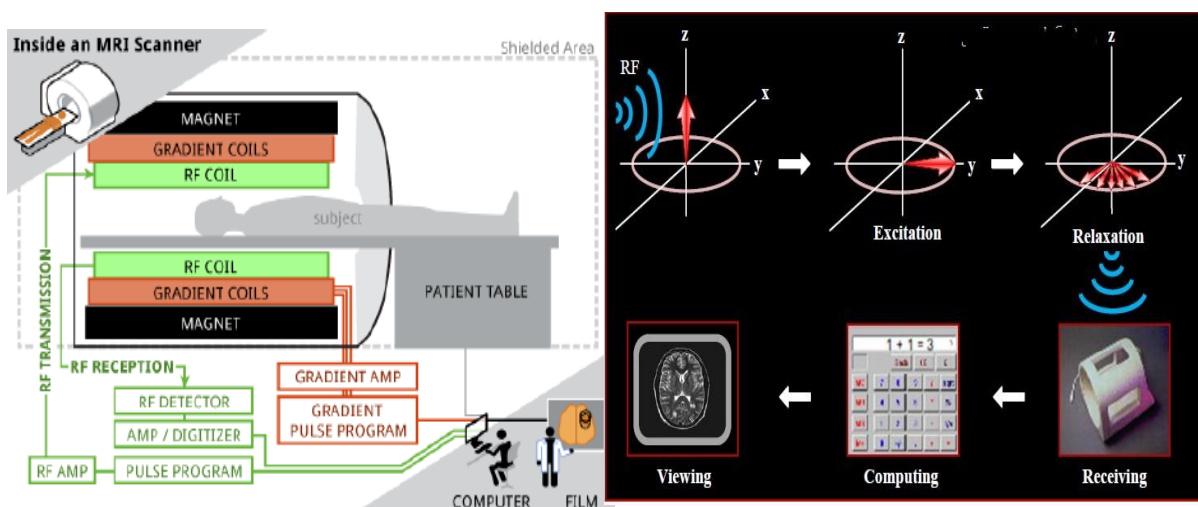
General Major Components of MRI system.
